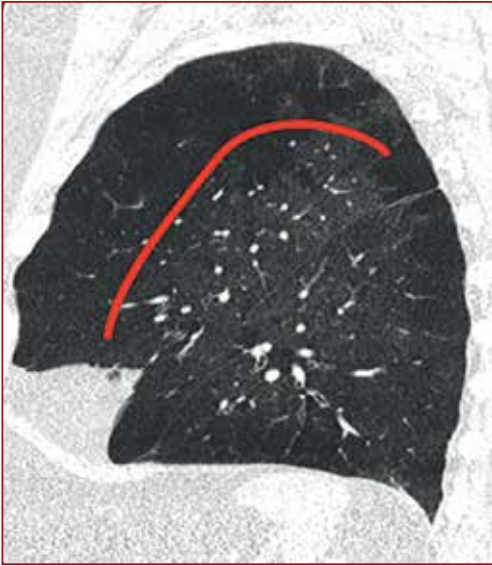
Sagittal CT scan in a patient with heterogeneous, upper-lobe predominant emphysema. The red line shows the potential resection line on the left side, preserving the central lung tissue with better quality.
